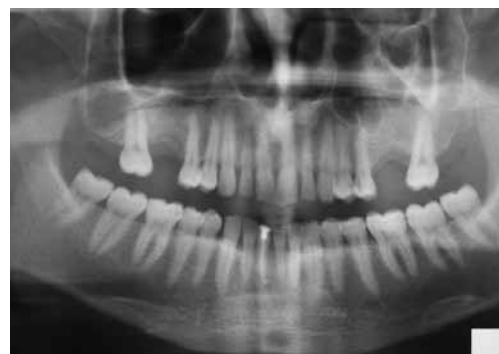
Panoramic Xray after 1 year. Satisfactory bony radio-opacity and neoformation, demonstrating a good healing ; note the repneumatization of the antrum.
